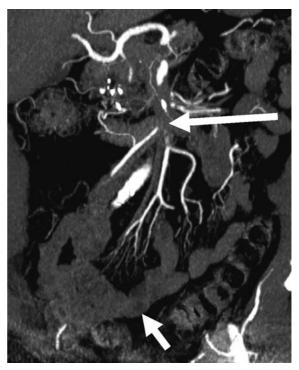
Small bowel ischemia in a 76-year-old male, coronal reformatted contrast-enhanced CT. Isolated proximal SMA embolus (*long arrow*), target sign of the small bowel wall (*short arrow*). There is only mild bowel ischemia because of retrograde perfusion of the SMA via collaterals from the celiac artery
